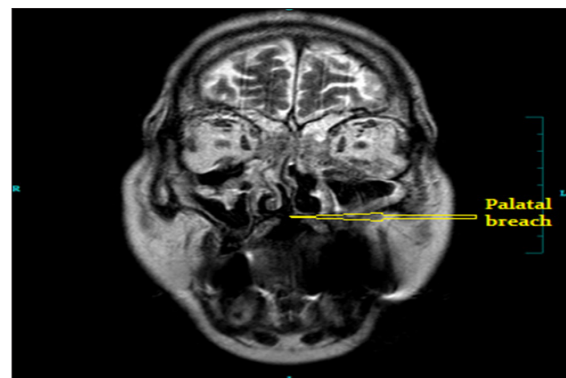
A Radiological Presentation of the Patient (T2 Weighted MRI) Showing Palatal Breach, absent Middle Turbinate and other Intranasal Structures as Compared to the Healthy Side that Correlates with the Clinical Findings of the Patient. There was no Paranasal Sinus Involvement, Intraorbital or Intracranial Spread at this Point of Time
